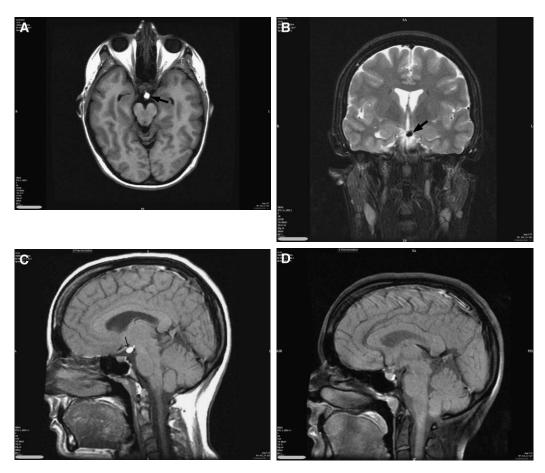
Small lipoma of the interpeduncular cistern just ventral to the basilar artery. (A) Axial T1-weighted (T1W) inversion recovery image reveals a small, round, high signal intensity lesion ventral to the midbrain and behind the pituitary gland in the interpeduncular cistern (arrow). (B) Coronal spin echo (SE) image demonstrates that the lesion darkens considerably on a heavily T2-weighted image (arrow). (C) Sagittal T1W SE image also reveals the high signal intensity lesion just above and behind the pituitary fossa in the interpeduncular cistern (arrow). (D) The key diagnostic images are the sagittal fat-suppressed T1W images, which reveal that the lesion is completely suppressed after the application of a chemically selective saturation pulse. This confirms the diagnosis of benign fat as opposed to tumor, hemorrhage, or other lesion.
